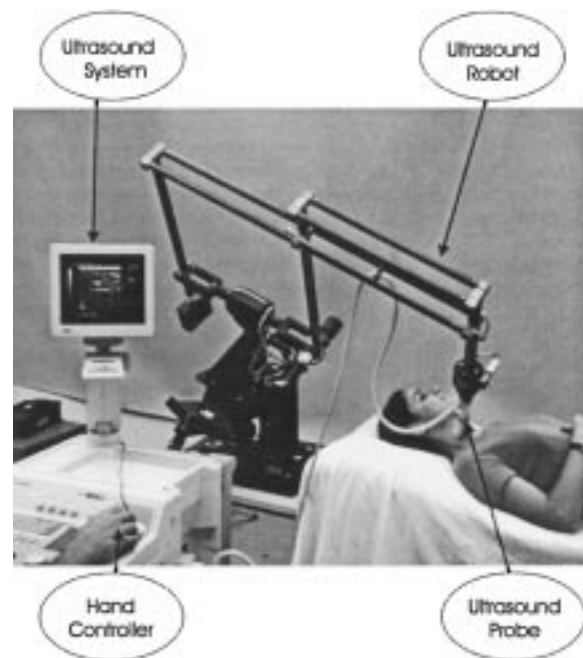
Experimental setup for robot-assisted ultrasound. The 6-DOF parallelogram linkage robot moves the ultrasound probe on the patient's neck for the carotid artery examination.
